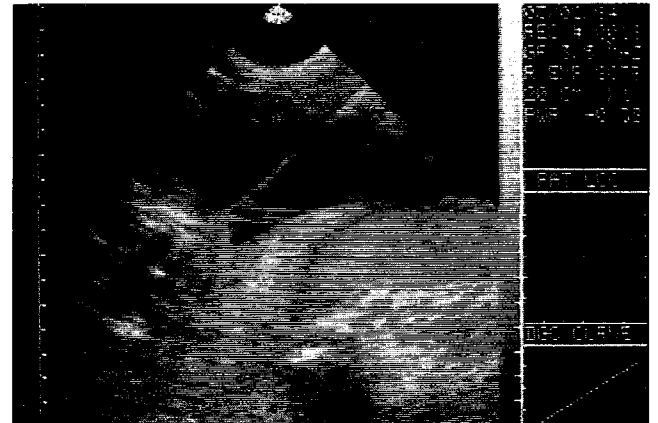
Intracardiac puncture under ultrasound guidance
